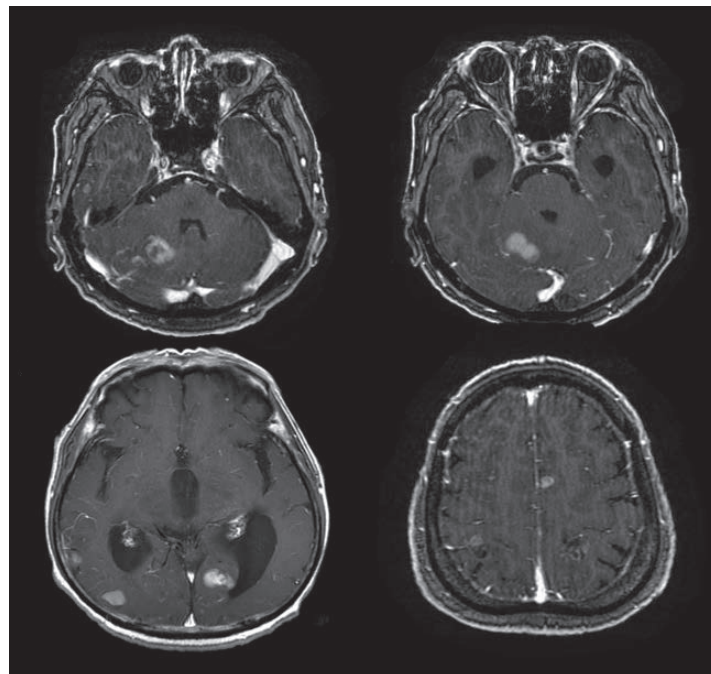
Contrast-enhanced magnetic resonance imaging performed 2 weeks after admission revealed intracerebral hemorrhage from multiple sites but could not identify any obvious contrast-enhanced lesions.
